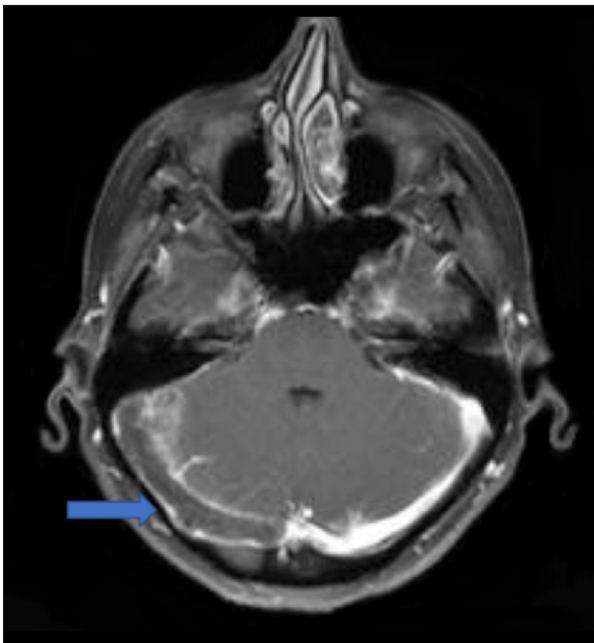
Axial view of contrast-enhanced magnetic resonance imaging (MRI) identifying no contrast within the transverse sinus (arrow) compatible with occlusion or thrombus.
